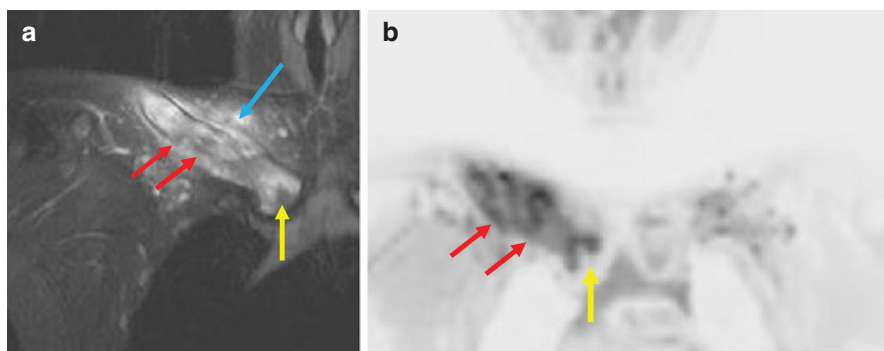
Chronic Clavicular TB Right clavicle: MRI T2 fluid sensitive (Image a) and Diffusion weighted Imaging (DWI) (Image b) Findings are of diffuse bone based abnormal signal on MRI with oedema and remodeling deformity, the latter reflecting chronicity. Associated sub-articular erosions at sternoclavicular articular surface and surrounding oedema. (Image courtesy Dr Afshin Alavi, Consultant Radiologist, Imperial College Healthcare NHS Trust UK)*
